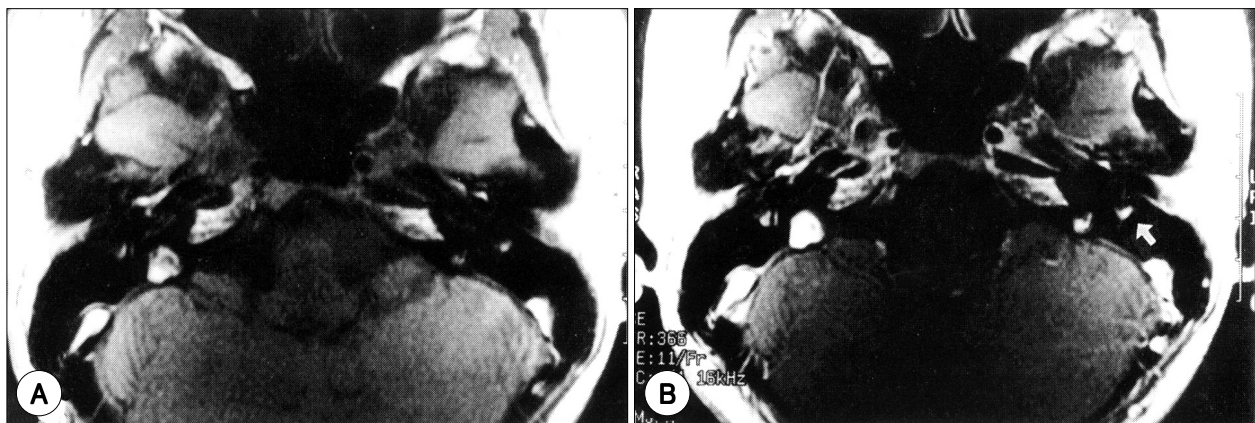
A : Precontrast magnetic resonance imaging. B : Enhancement of mastoid segment of the facial nerve (white arrow).
